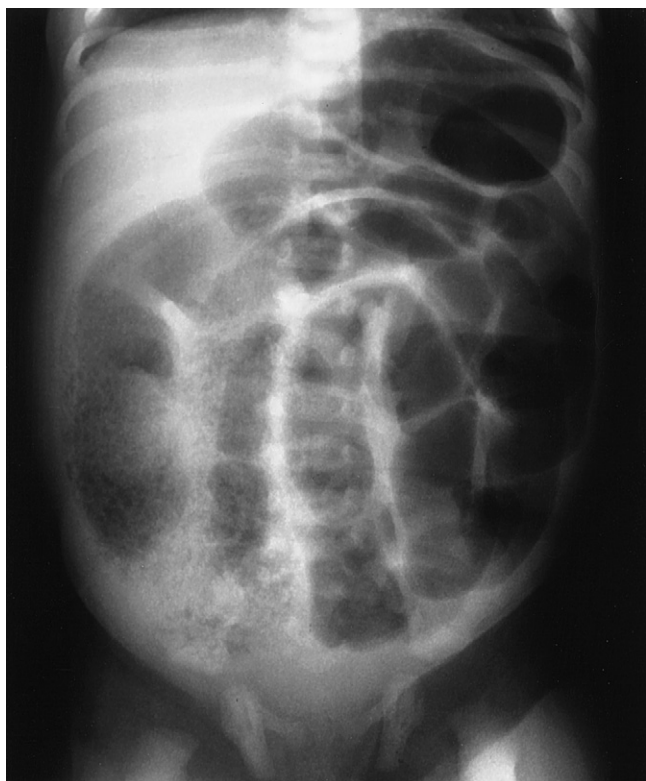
An abdominal plain upright radiograph is compatible with the diagnosis of meconium ileus. There are dilated small bowel loops of disparate size, few air-fluid levels, and a “ground-glass” or “soap-bubble” appearance in the right lower quadrant. (From Rescorla FJ, Grosfeld JL: Contemporary management of meconium ileus. *World J Surg* 1993;17:381.)
